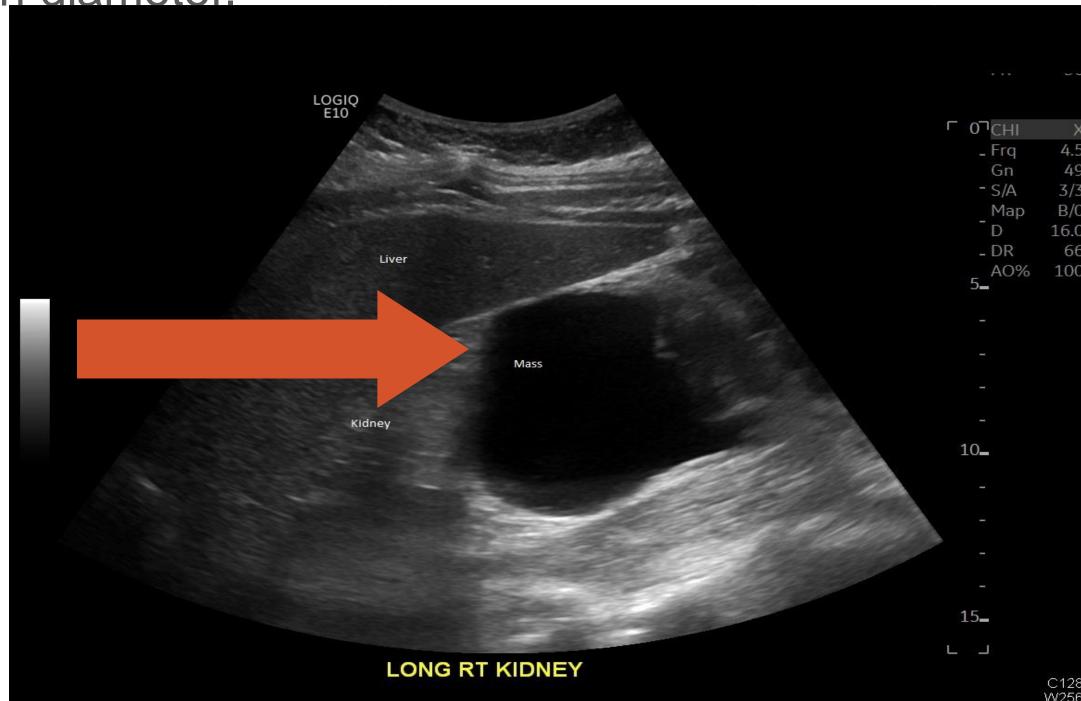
An ultrasound was preformed to further evaluate the mass on 04/29/21, which revealed an 11.4cm right renal cyst.
